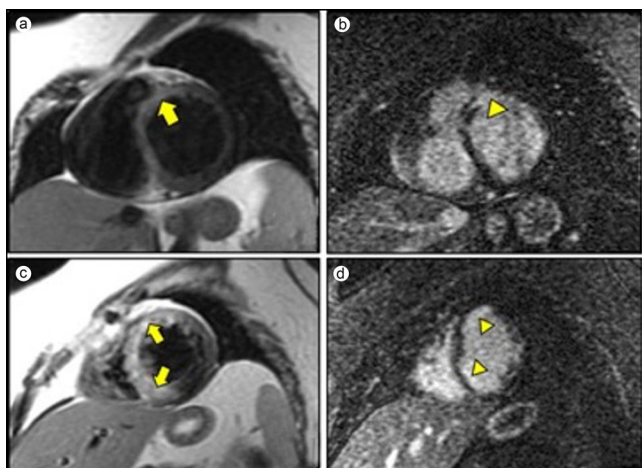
Cardiac magnetic resonance imaging. (a, b) Short axis images through the heart showing patchy edema on T2 images (arrows), (c, d) with corresponding areas of patchy mid-myocardial and sub-endocardial late gadolinium enhancement (arrowheads).
